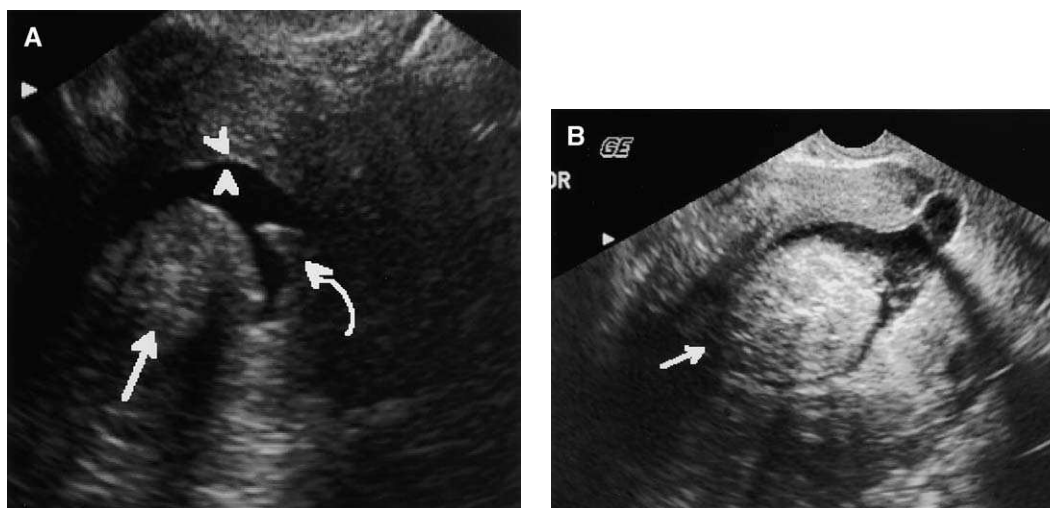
(A, B) Coronal and sagittal SHG in two different postmenopausal patients with bleeding demonstrates submucosal fibroid (arrows). These lesions could not be distinguished sonographically from polyps because the endometrial layer over the lesions is atrophic and is not visualized. Definitive characterization with biopsy proved that these lesions were fibroids. A more typical appearing endometrial polyp also was found in the first patient (curved arrow).
